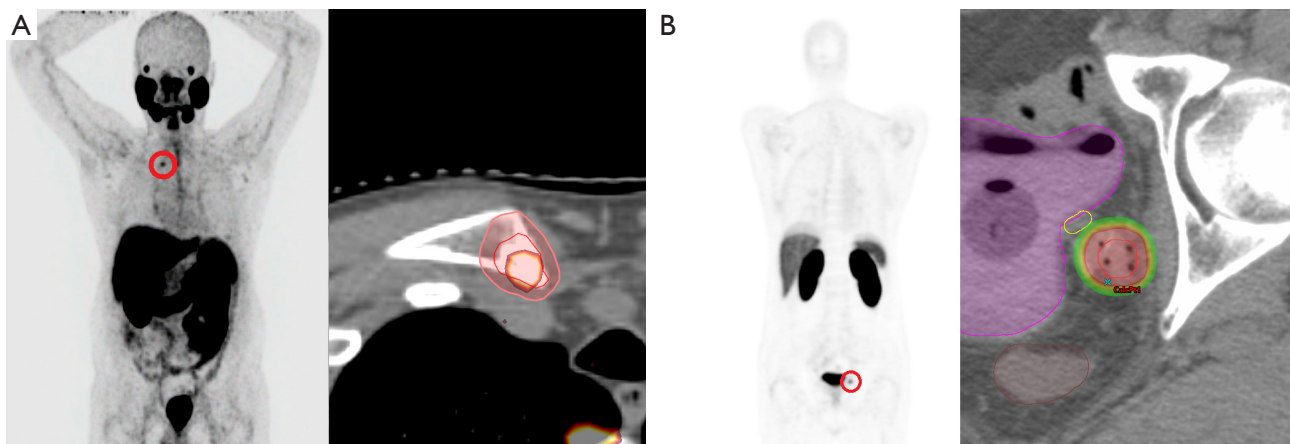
PSMA PET in guiding radiation for recurrent prostate cancer. Red circles represent PSMA avid lesions. (A) A 56-year-old male who underwent prostatectomy for localized high-risk prostate cancer followed by androgen deprivation and radiotherapy to the pelvis/prostate bed, found to have PSA elevation of 0.2 ng/mL 3 years later. PSMA PET showed a small uptake in the right clavicular head. SBRT 27/30 Gy [PTV (pink contour)/GTV (red contour)] in 3 fractions done as shown and he remains disease-free without further therapy 2 years after SBRT. (B) A 61-year-old male who underwent prostatectomy for localized high-risk prostate cancer followed by prostate fossa radiotherapy. Five years later, PSA 2.0 ng/mL, with PSMA PET showing small uptake in the left seminal vesicle remnant. Patient underwent interstitial HDR brachytherapy 36 Gy in 4 fractions [GTV (red contour)/bladder (purple contour)/rectum (brown contour)/ureter (yellow contour)]. Post treatment PSA down to 0.8 ng/mL. At 6 months post treatment, no signs of disease on PSMA PET. PSMA, prostate specific membrane antigen; PET, positron emission tomography; PSA, prostate specific antigen; SBRT, stereotactic body radiotherapy; PTV, planning target volume; GTV, gross tumor volume; HDR, high dose rate.
